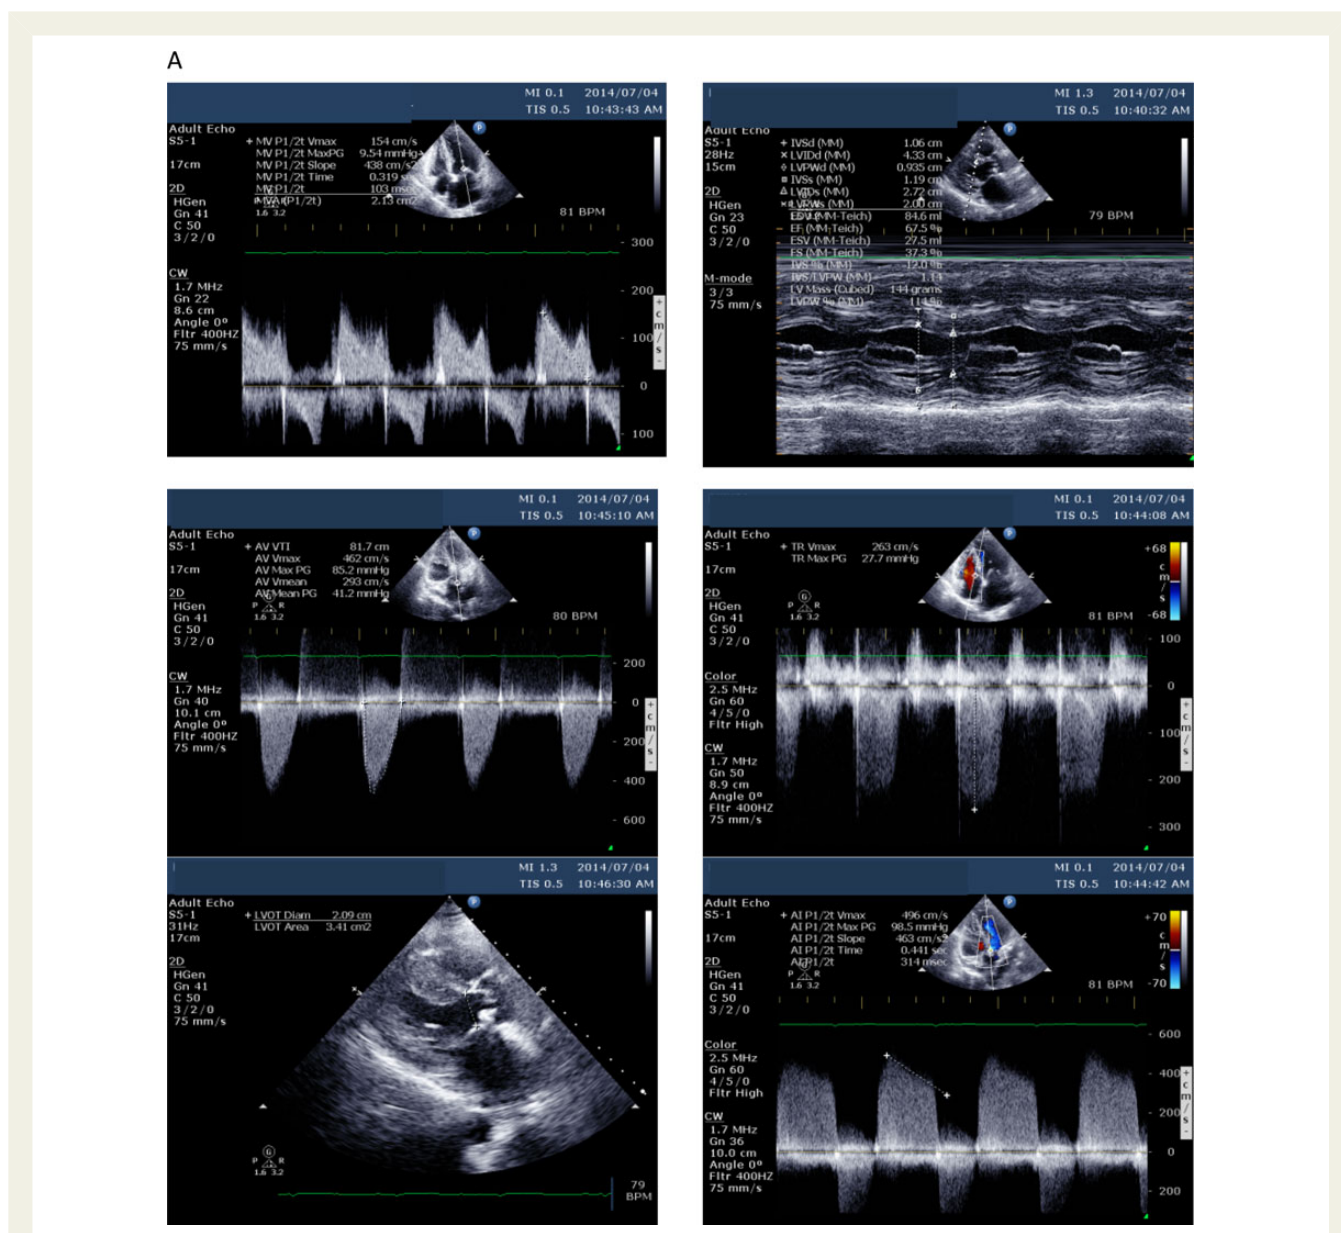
(A) 26-year-old female with rheumatic heart disease—mixed aortic valve disease and mild–moderate mitral stenosis. Figure shows continuous wave Doppler of the mitral valve lesion, left-ventricular parameters assessed by M-mode, 2-D images and pressure gradients of the aortic valve. (B) 24-year-old female with double valve replacement (mitral and aortic position) with post-operative preserved left-ventricular systolic function.
